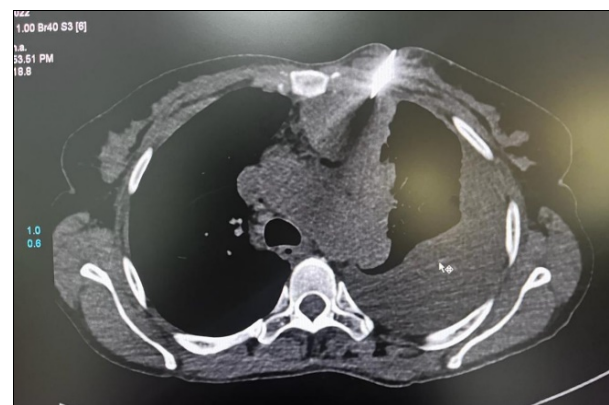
CT guided biopsy of anterior mediastinal mass.
